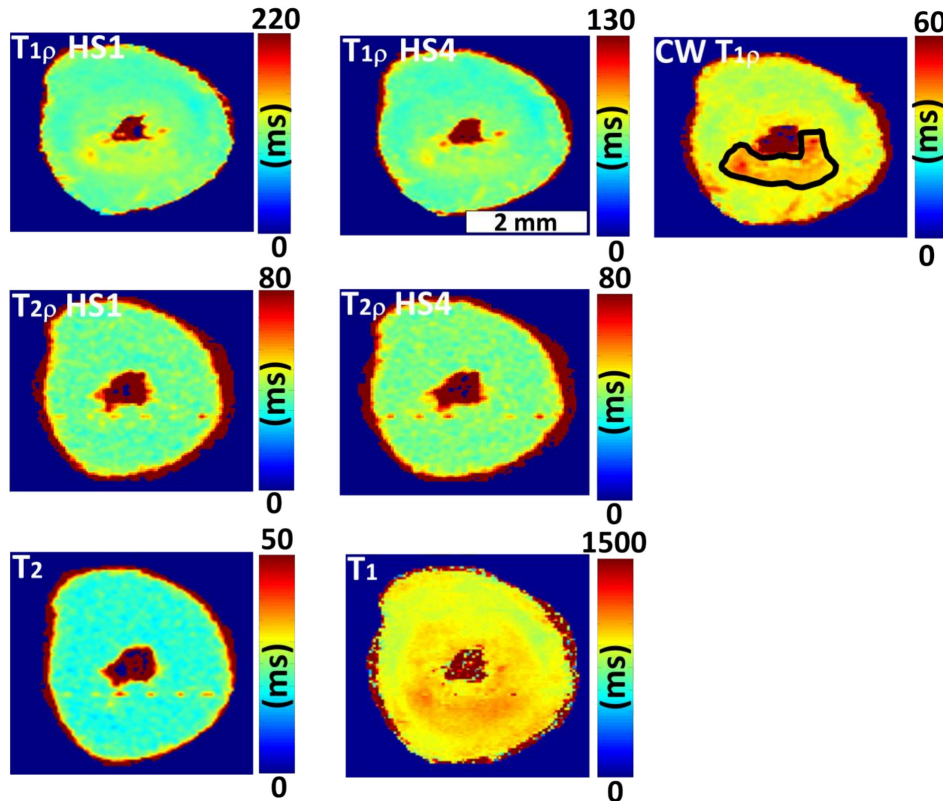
Ex vivo relaxation time maps after 2h of LAD occlusion with different rotating frames and conventional MRI methods. The outline of the selected ROI of infarct is presented with a black line in CW $T_{1\rho}$, and it was used in all relaxation time maps.
